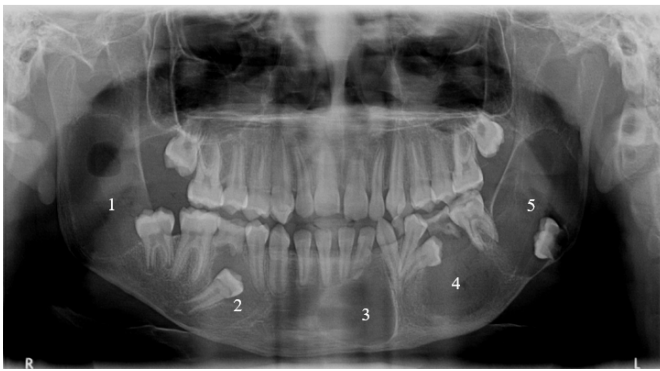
Panoramic radiograph showing five mandibular cystic lesions, well delineated by radiopaque margins. 1) Extensive lesion located in the right mandibular ramus involving tooth 47. 2) Cystic lesion in the right mandibular body involving the unerupted tooth 45. 3) Cystic lesion in the anterior mandibular region. 4) Lesion located in the left mandibular body involving the unerupted teeth 35 and 75. 5) Extensive lesion in the left mandibular ramus involving the unerupted tooth 37.
